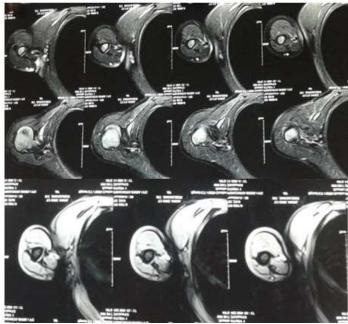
Cross sectional T1 and T2 MRI images showing both glenoid and humeral head hypoplasia
